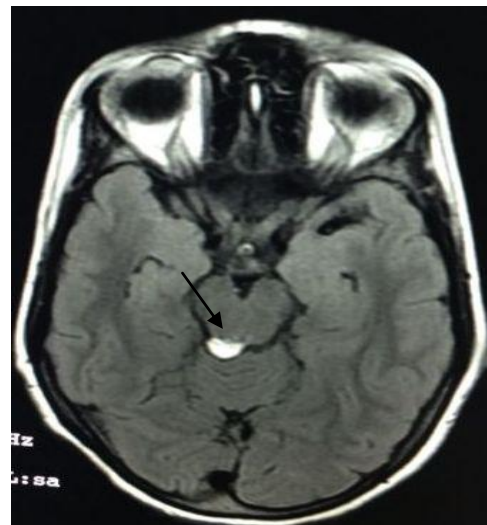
T1 weighted MRI scans reveals homogenous intensely hyperintense lesion in the right quadrigeminal cistern
